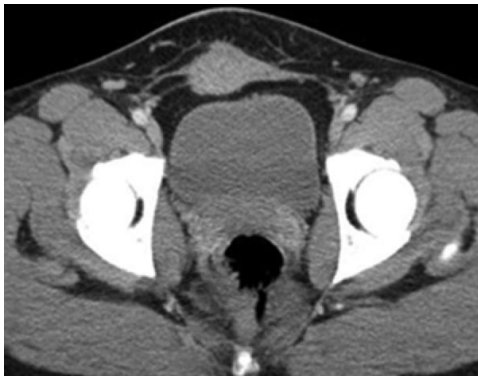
Contrast-enhanced CT image shows a slightly hyper attenuating soft-tissue nodule in the anterior pelvic wall along a prior surgical scar with infiltration of adjacent fat planes.
